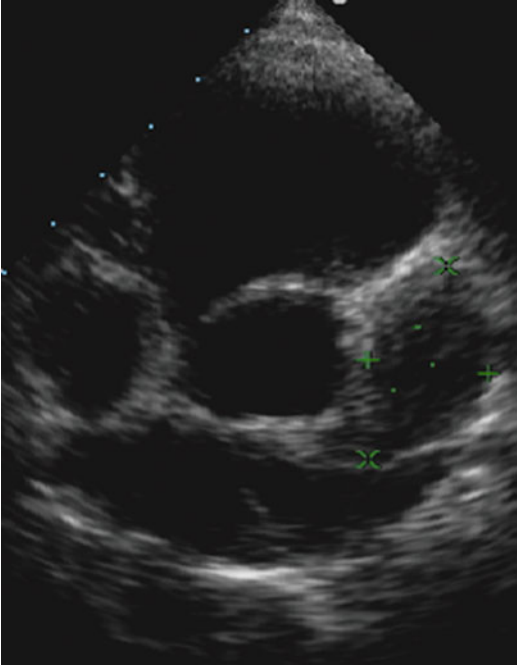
CAA; echocardiography (LAD)
